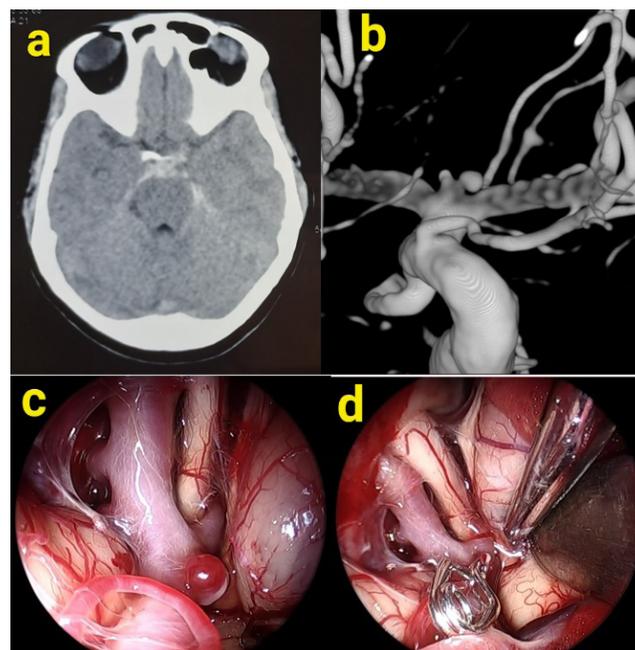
MRI scan and operative findings of ICA aneurysm
